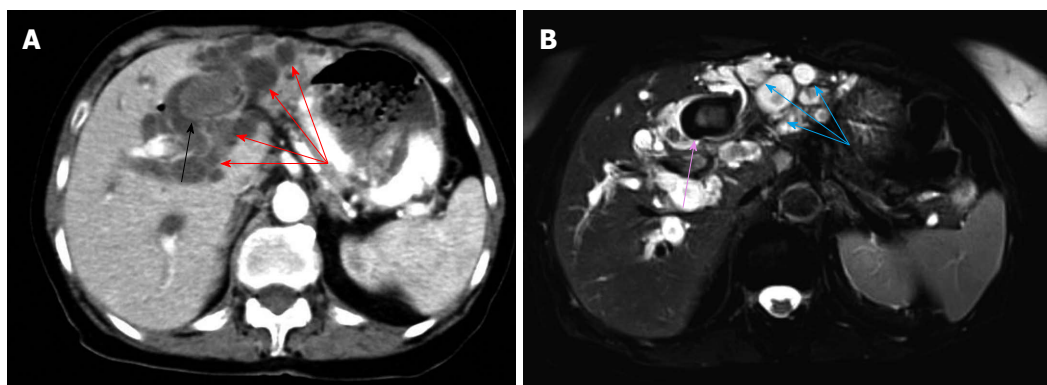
A case of Caroli disease. A: On computed tomography. A large intra-biliary stone (black arrow) is evident in the dilated ducts (red arrows); B: On magnetic resonance imaging. A large intra-biliary stone (pink arrow) is evident in the dilated ducts (blue arrows).
